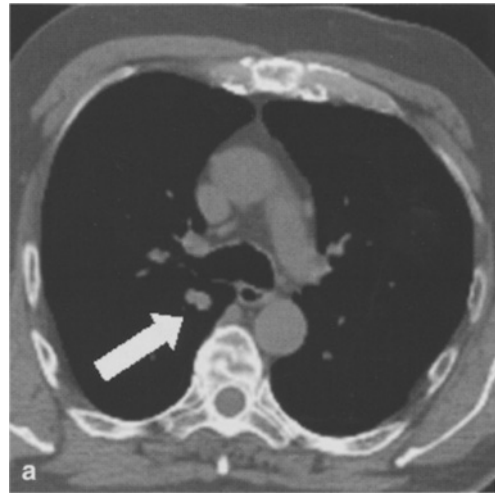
a Contrast enhancement measurements from a pulmonary nodule of indeterminate nature on a conventional CT images (*arrow*). b The peak enhancement value is 50 HU, equivalent to an *SPV* of 5.1. As the nodule is highly perfused (peak enhancement >15 HU, *SPV*>1.6), it cannot be considered benign; however, tumours and inflammatory lesions, such as granulomata, may exhibit high perfusion values; thus, further investigation (e.g. fluorodeoxyglucose PET or fine-needle aspiration) is required
